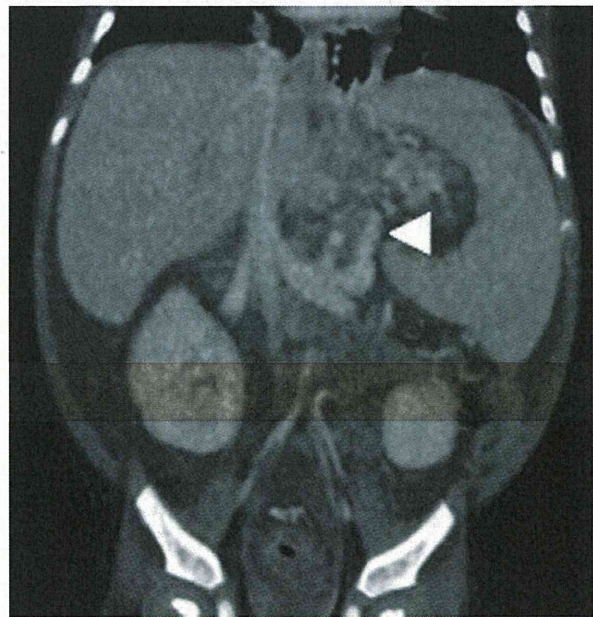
Pre-operative CT angiography showed LSRS (arrowhead) in 3D reconstruction image.
